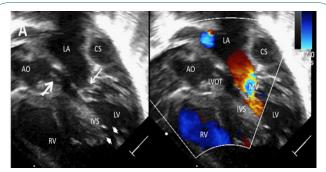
(A) Apical 5 chamber view in two-dimensional echocardiography (left) with color-flow Doppler (right) depicting stenotic MV (thin arrow), LVOT obstruction (thick arrow), large apical VSD (arrow heads) and dilated CS.
